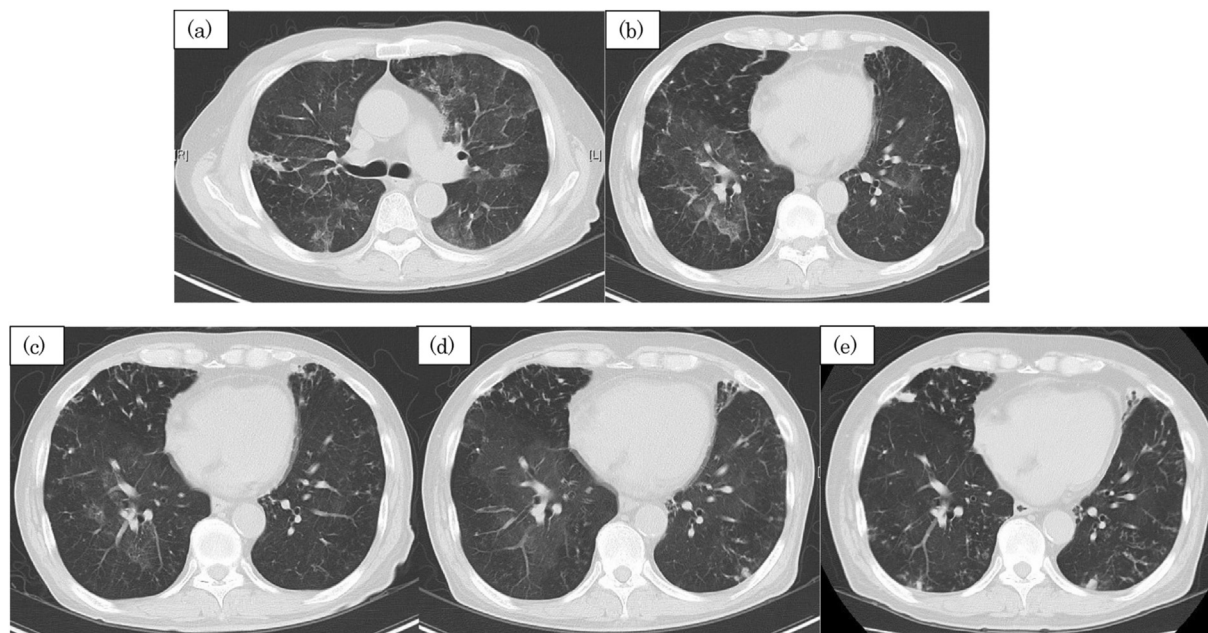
Serial computed tomography (CT) findings in the husband. (a), (b); CT scan at first admission in October 2013 shows bilateral ground glass opacities and nodular shadows in both lung fields. (c); CT scan 3 weeks after the first admission shows remarkable improvement in the ground glass opacities. (d); CT scan at the second admission in June 2014 once again shows bilateral ground glass opacities. The bilateral nodular shadows have increased in comparison to the first admission and bronchiectasis has appeared in the left lingual lobe. (e); CT scan from August 2015 shows minimal persistence of the bilateral ground glass opacities. Diffuse bilateral nodular shadows persist.
